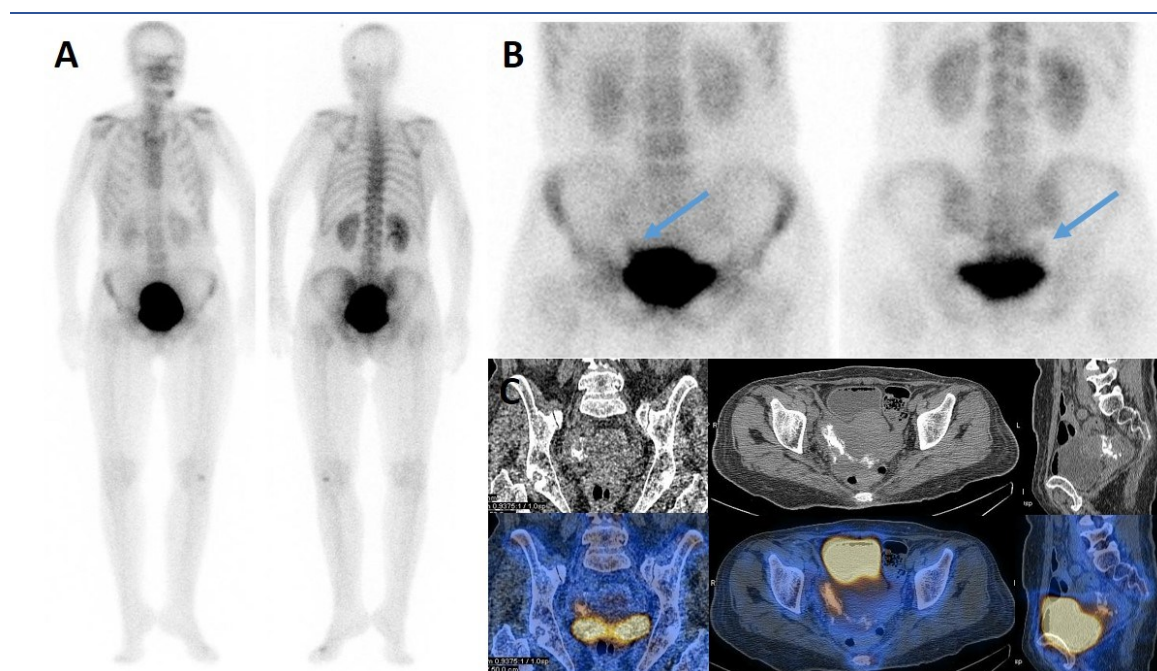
The whole body scan revealed foci of uptake in the skull, which were subsequently confirmed as contamination (A). The post-void pelvic static images demonstrated a suspicious, smeared uptake in the right side of the pelvis, supero-lateral to the bladder (B, blue arrow). SPECT/CT images localized the zone of uptake in the right side of the bladder to areas of calcification within a solid cystic mass in the right ovary
